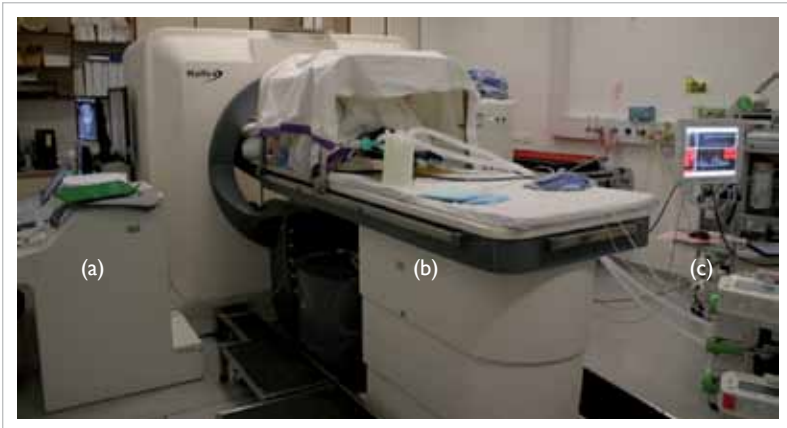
The usual setup of the high-intensity focused ultrasound (HIFU) system (a) Control system; (b) HIFU machine and patient lying on the treatment table; and (c) anaesthetic machine
